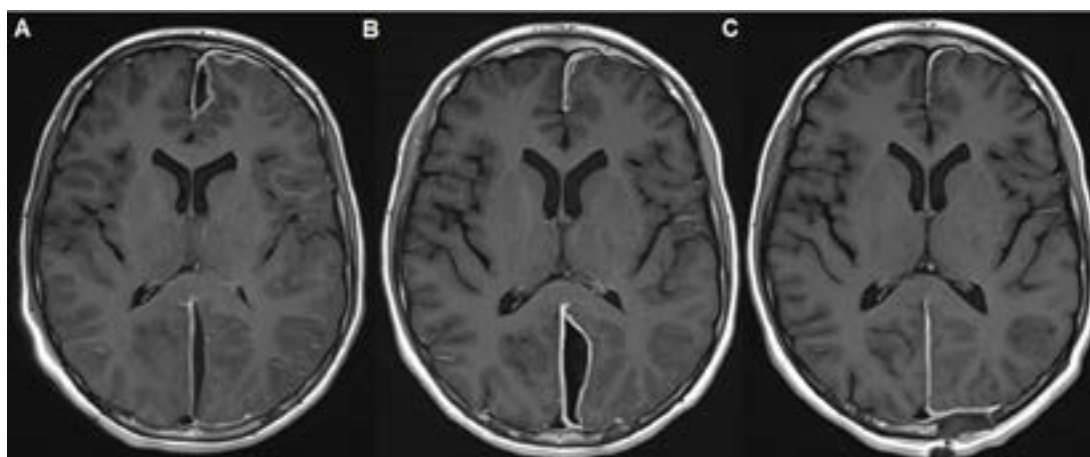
Evolution of the subdural empyema. Axial T1-weighted images after Gadolinium administration on admission (A), day 13 (B) and day 21 (C). Between the scan on admission (A) and day 13 (B) a clear volume-increase of the dorsal component of the subdural empyema can be seen. Control MRI on day 21 shows complete regression of the subdural empyema with some residual most likely reactive left parafalcine dural enhancement (C).
